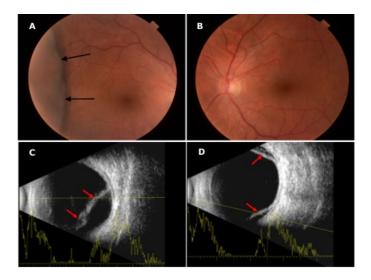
Fundus photographs and ultrasound B-scans taken of the eyes of Patient 2. Picture A: black arrows show the central border of the temporal choroidal effusion in the RE. Picture B: in the LE the the very shallow and peripheral lesion could not be displayed by the OCT camera (question mark). In picture C and D, the red arrows are pointing at the highly reflective membranes corresponding to the inner aspects of the RE's higher and the LE's shallower choroidal detachments. Retinal detachment did not presented in either eye.
